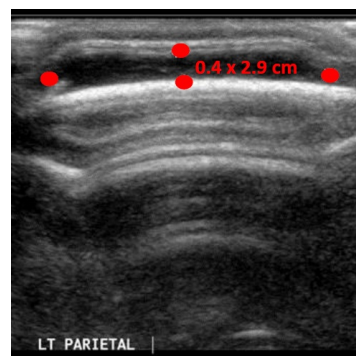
Ultrasound cranium/brain showing reduced left subgaleal hematoma.
